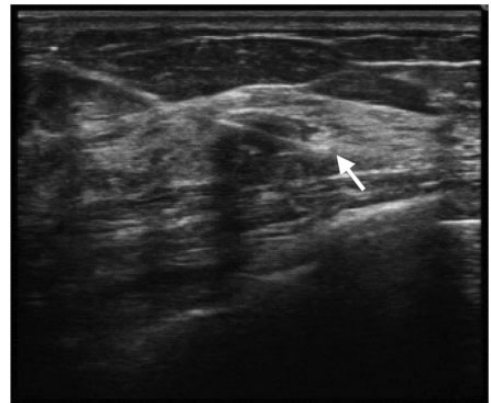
Ultrasound guidance was used to place wires.
